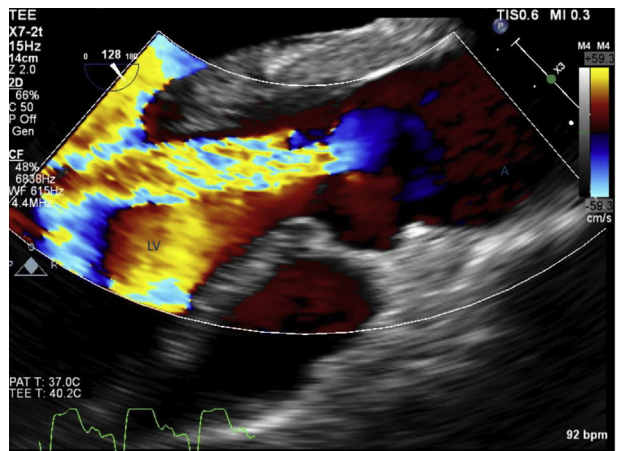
Long-axis TEE view with color Doppler showing moderate aortic regurgitation. A, Aorta; LV, left ventricle.
